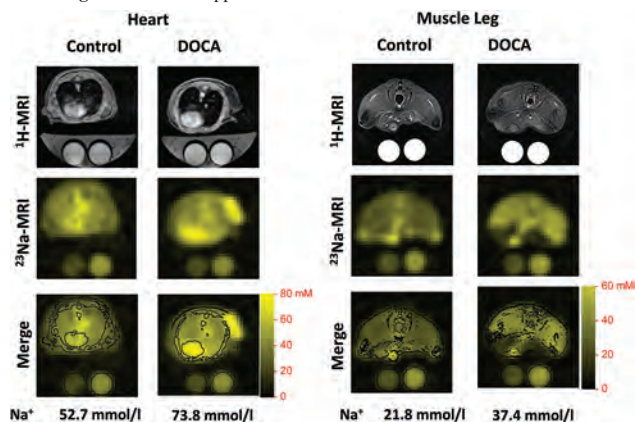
representative MR images.
